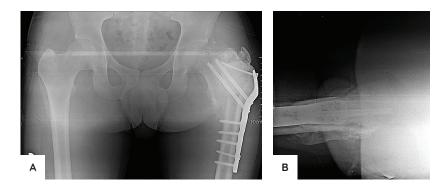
Femur AP (A) and lateral (B) radiographs showing PMMA and proximal femoral locking plate.
